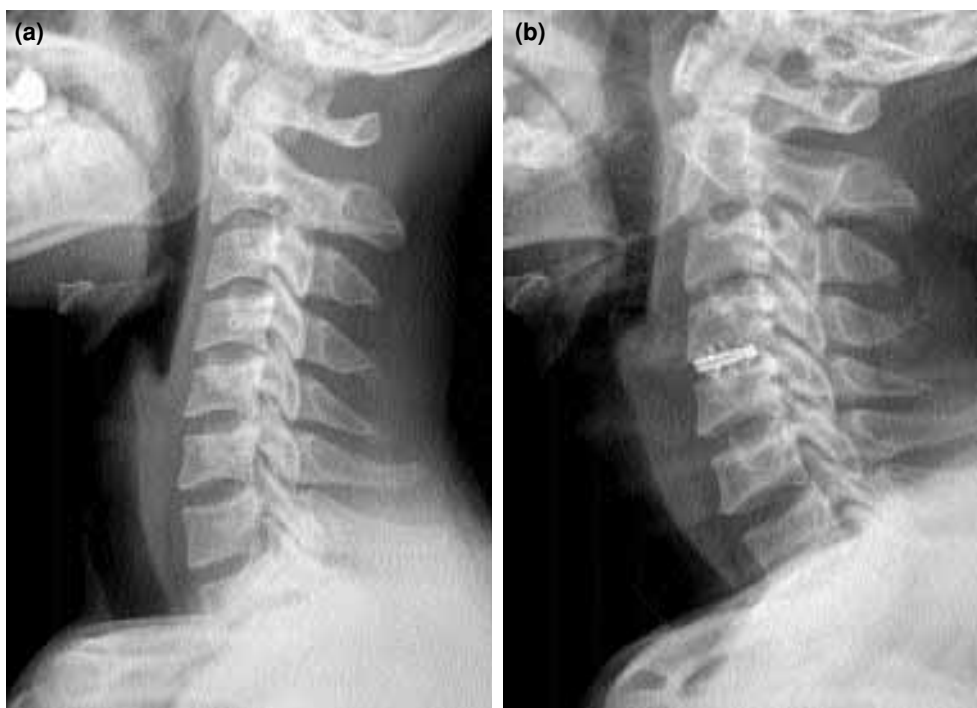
Comparison of (a) preoperative and (b) postoperative X-rays showing improvement in lordotic alignment after surgery.
